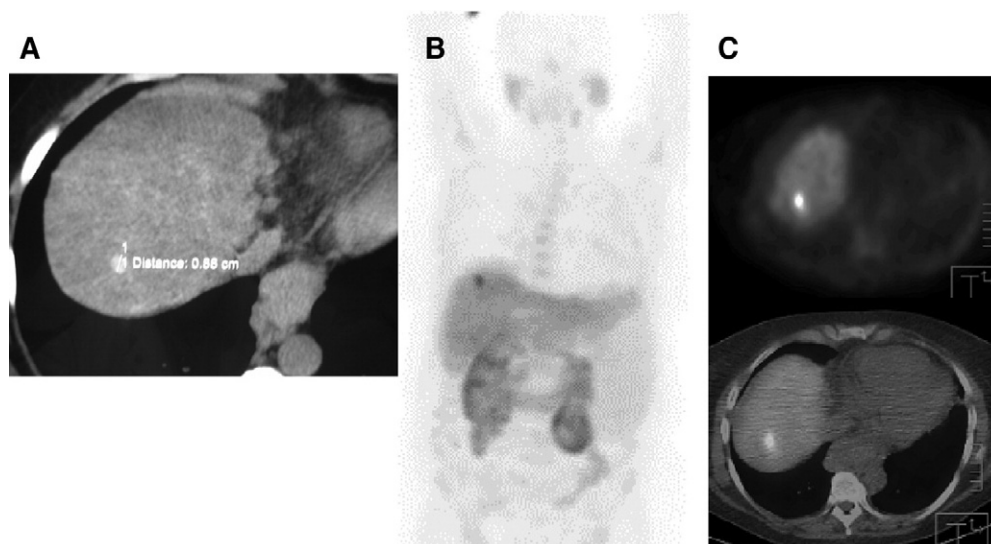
Recurrent hepatocellular carcinoma in a patient with alcoholic cirrhosis. Serum alpha-feto protein levels were elevated at 1,250 ng/mL. On CT, a 9-mm nodule was found in the segment VII of the liver (A). The lesion demonstrated significant FCH uptake relative to surrounding liver, as shown on maximum intensity projection image (B) and corresponding FCH PET (C, top) and PET/CT images (C, bottom).
